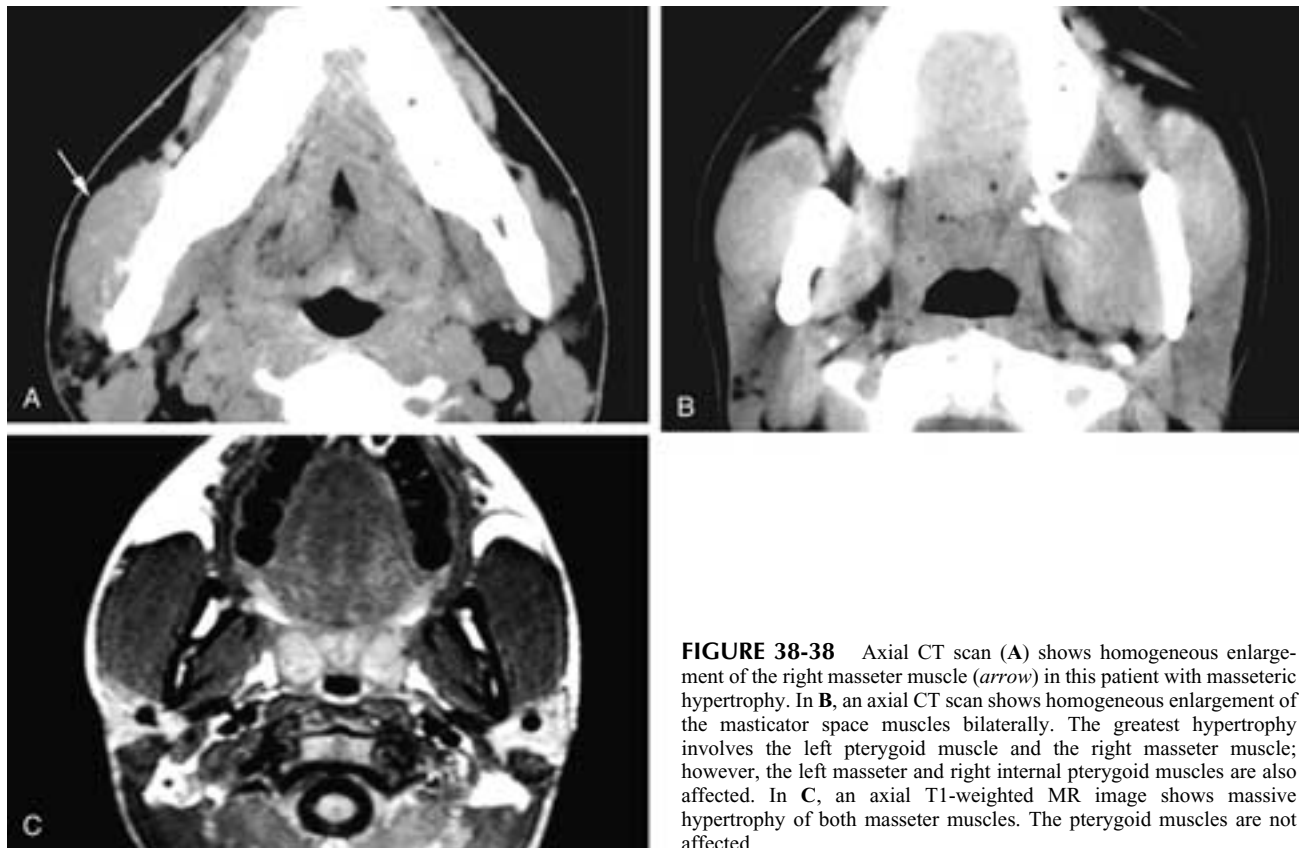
Axial CT scan (A) shows homogeneous enlargement of the right masseter muscle (arrow) in this patient with masseteric hypertrophy. In B, an axial CT scan shows homogeneous enlargement of the masticator space muscles bilaterally. The greatest hypertrophy involves the left pterygoid muscle and the right masseter muscle; however, the left masseter and right internal pterygoid muscles are also affected. In C, an axial T1-weighted MR image shows massive hypertrophy of both masseter muscles. The pterygoid muscles are not affected.
